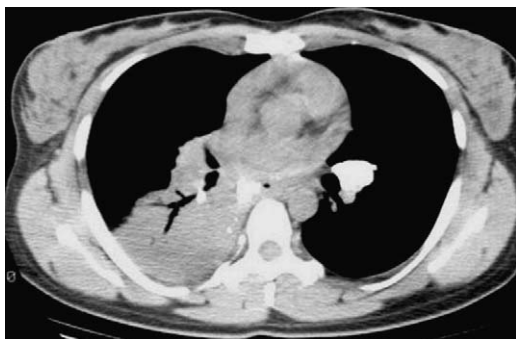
CT scan of a broncholith causing postobstructive air space disease.
